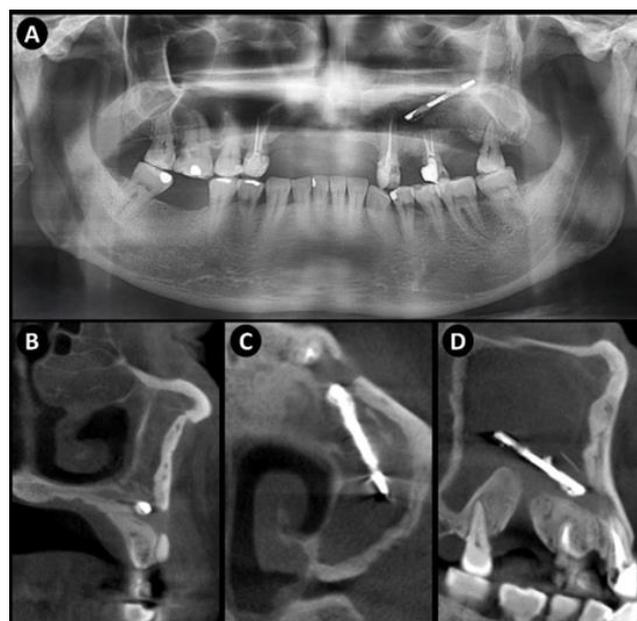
Preoperative imaging exams. A – Panoramic radiograph. B – Cone beam computed tomography (CBCT), coronal reconstruction. C – CBCT, axial reconstruction. D – CBCT, sagittal reconstruction.
